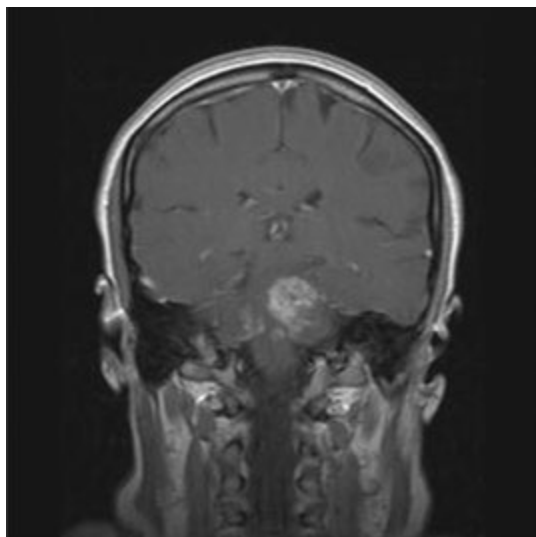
Brain MRI with gadolinium contrast. There is uptake in multiple areas (white areas) indicating inflammatory lesions within the brain due to neurosarcoidosis.
